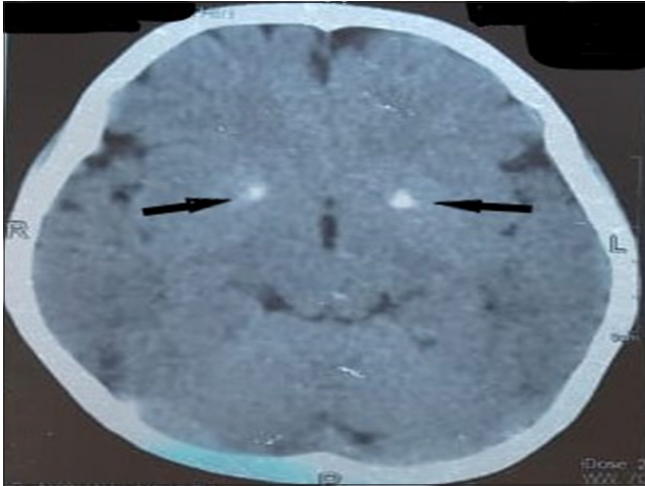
Computed tomography brain showing symmetrical foci of calcifications in bilateral basal ganglia indicated by black arrows.
